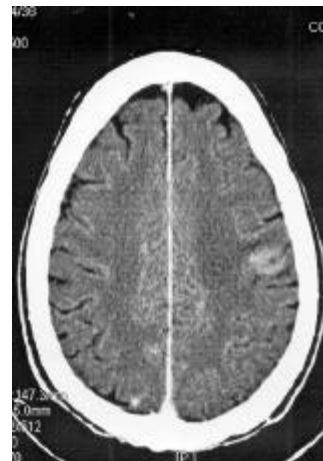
CT scan of a brain metastasis from NSCLC responding to gefitinib therapy. This patient had been pretreated with three lines of chemotherapy including platinum and taxanes, and received gefitinib after whole-brain radiotherapy failure. Reproduced with permission from: Cappuzzo F, Calandri C, Bartolini S, Crino L. ZD1839 in patients with brain metastases from non-small-cell lung cancer (NSCLC): report of four cases. *Br J Cancer* 2003, 89, 246–247.
